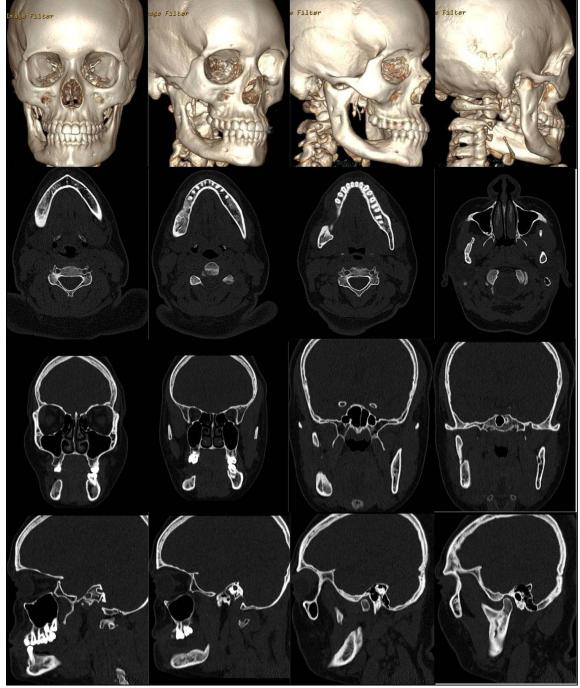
Postoperative CT images at a 1-year follow-up showed healthy bone neoformation and no recurrence of the lesion.
